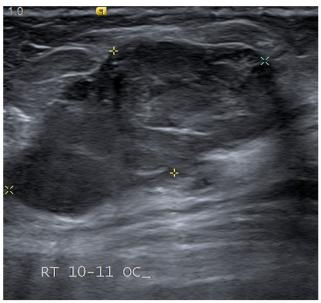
Ultrasound image of a heterogeneous breast lesion at right 10-11 o'clock (BIRADS 2). Biopsy was performed in view of the palpable lesion. HPE finding was invasive carcinoma with mucinous differentiation.
